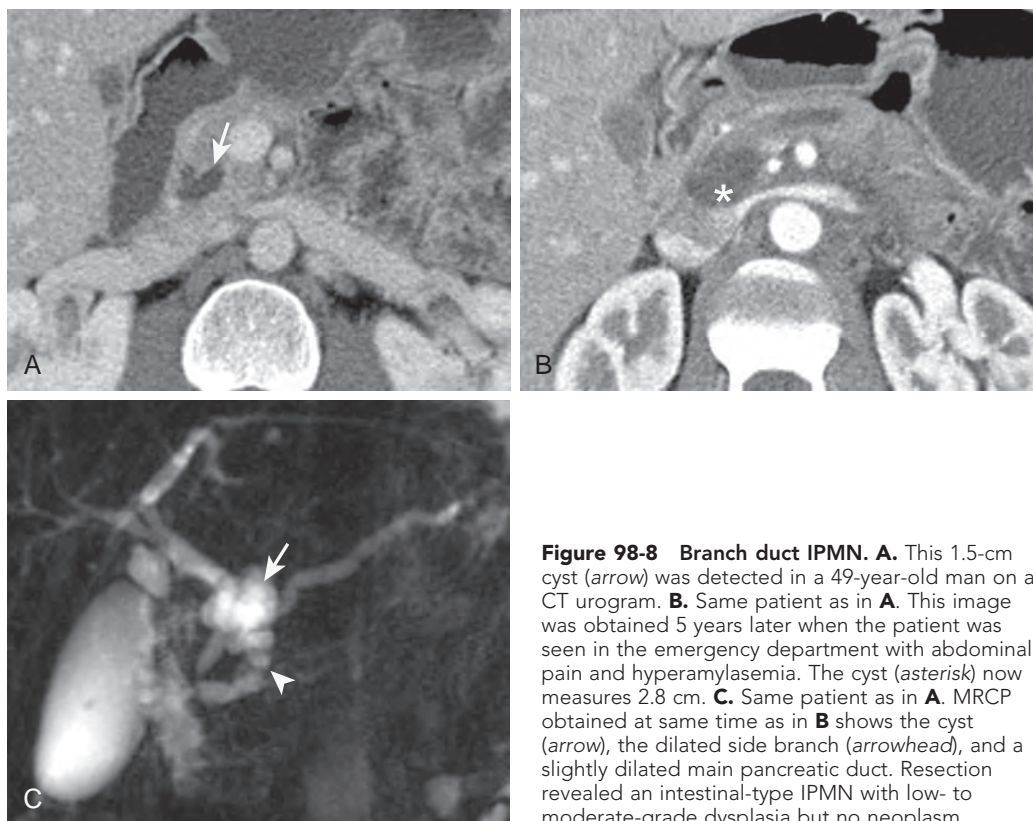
Branch duct IPMN. A. This 1.5-cm cyst (arrow) was detected in a 49-year-old man on a CT urogram. B. Same patient as in A. This image was obtained 5 years later when the patient was seen in the emergency department with abdominal pain and hyperamylasemia. The cyst (asterisk) now measures 2.8 cm. C. Same patient as in A. MRCP obtained at same time as in B shows the cyst (arrow), the dilated side branch (arrowhead), and a slightly dilated main pancreatic duct. Resection revealed an intestinal-type IPMN with low- to moderate-grade dysplasia but no neoplasm.
